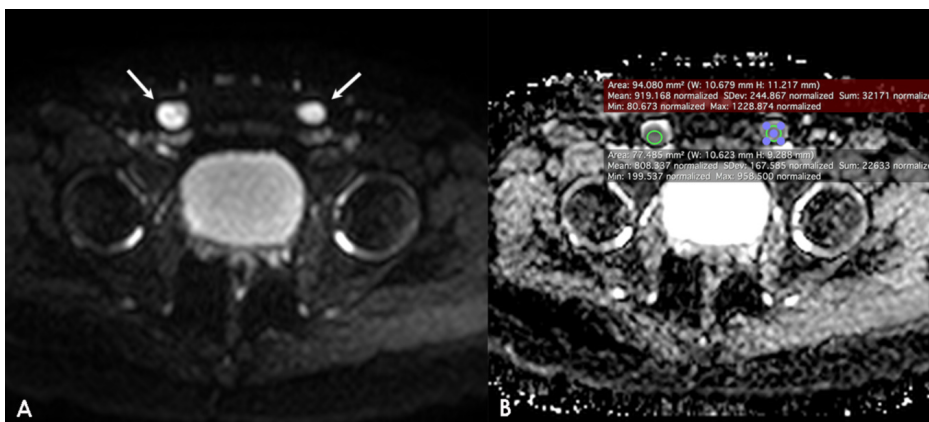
DWI demonstrates hyperintense signal of the extrapelvic gonads; ADC map shows bilateral low signal intensity with 0.8 mm²/s on the right and 0.9 mm²/s on the left. No signs of malignant degeneration are detected.
